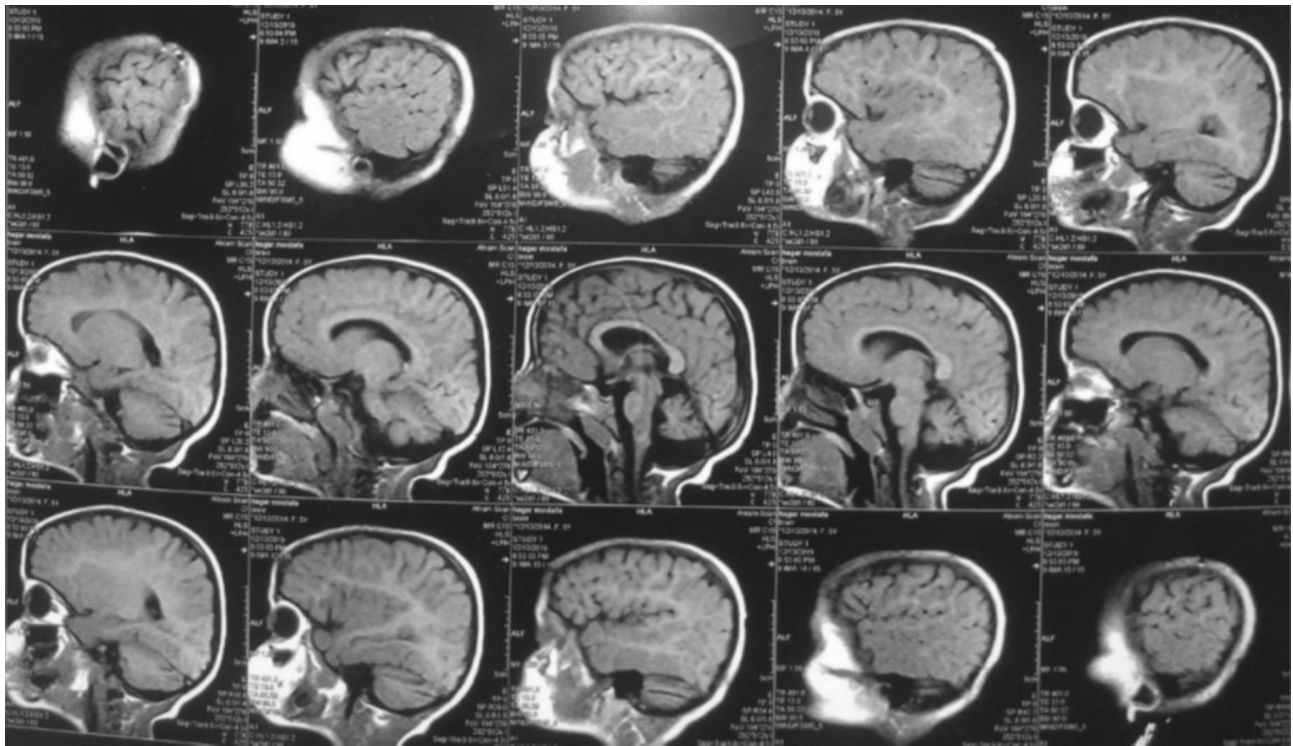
MRI brain (sagittal view) revealing cerebellar vermis atrophy. MRI, magnetic resonance imaging.
